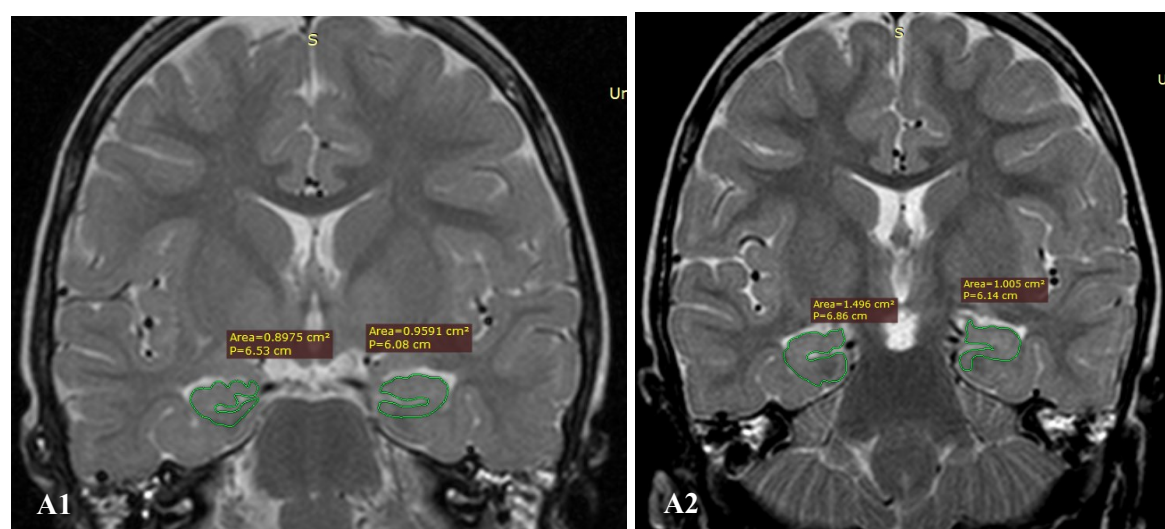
An example of head MRI scans of patients with hippocampal volume asymmetry, who developed epilepsy later on. A1,2 – 2 years old boy with 15 minutes long focal clonic seizure with secondary generalization.
